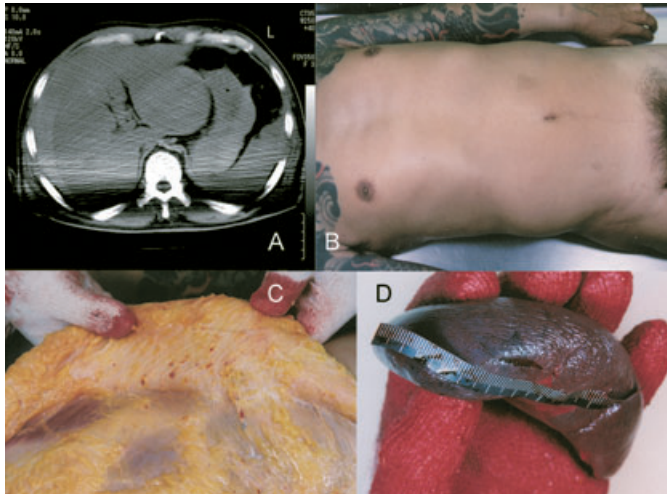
A case of misdiagnosed spleen rupture. A 55-year-old man complained of a stomach ache and subsequently suffered cardiopulmonary arrest. He was taken to the hospital by ambulance and later confirmed dead. A computed tomography scan in the hospital showed a large tumor in the liver and bleeding in the abdomen (A). With no external damage observed in the abdominal area (B), the doctor determined that the man died from blood loss caused by a ruptured hepatoma and did not report the case to the police. Immediately before the body was taken to the crematorium, those involved informed the police that the man had been beaten, which led to a forensic autopsy. The autopsy showed a subcutaneous dot hemorrhage, suggesting external forces applied to the abdomen (C), and damage was observed in the spleen (D). These findings indicated that the cause of death was a spleen rupture attributed to blunt force injuries to the abdomen.
